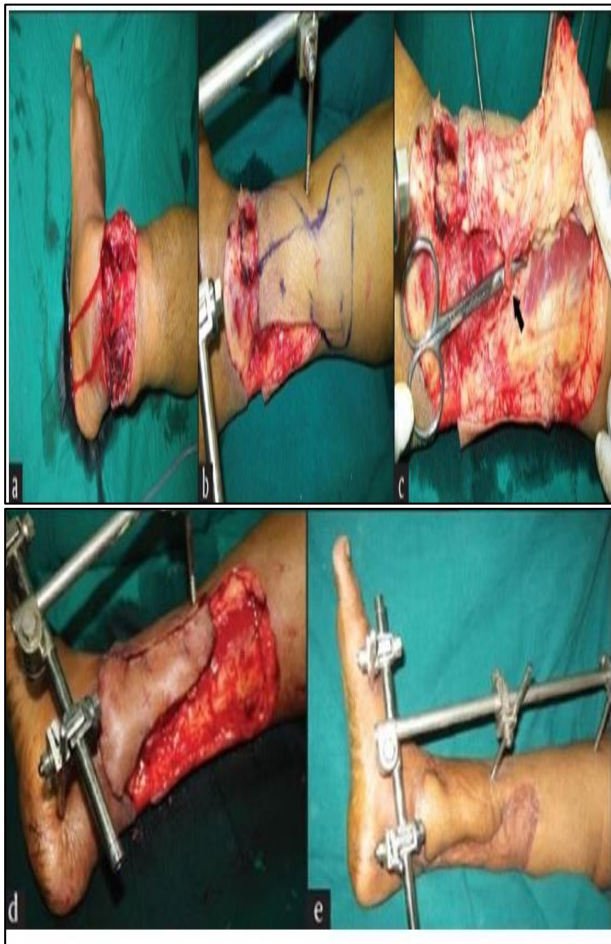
(A-E): A major crush injury of the lower third of the leg, the defect after debridement and the Doppler examination showed good audible signals at X, and a flap marked, the proposed flap elevated on one side and the perforator visualized before the whole flap is raised, the flap raised and rotated through 180 degrees to cover the critical area and a well-settled flap and the healed donor area.
